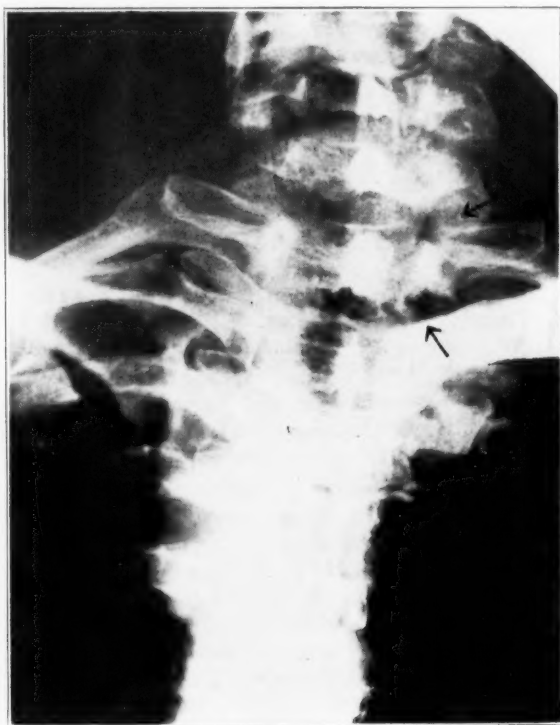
(case 8).—Anteroposterior roentgenogram of the spine, showing the enlarged intervertebral foramen between the seventh cervical and first dorsal vertebrae on the right (upper arrow), and erosion of the body and lamina of the first dorsal vertebra on the right (lower arrow).
